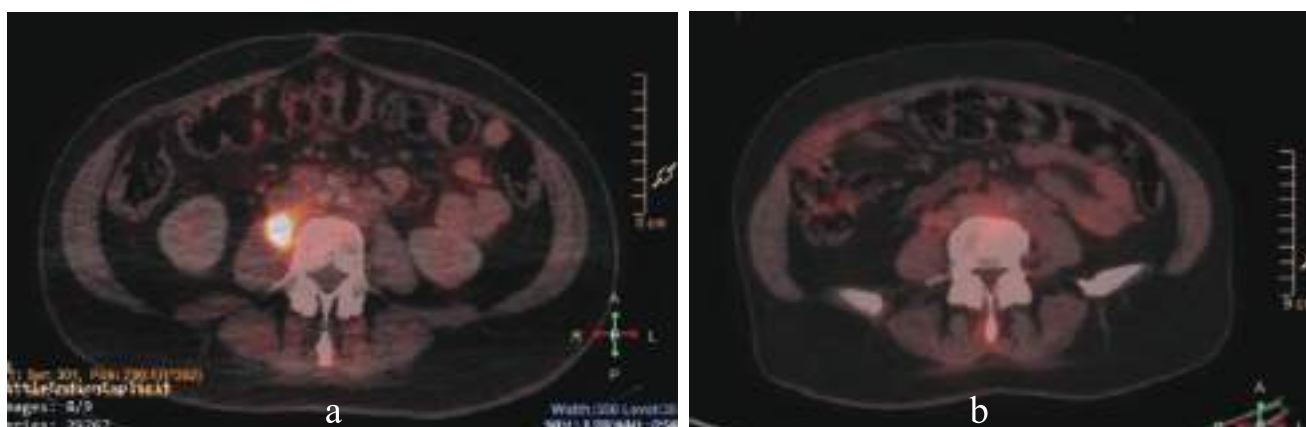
Transaxial fusion F-18 FDG PET-CT images showing complete regression of hypermetabolic lesion in right psoas major muscle (b) which was present in previous scan (a).
